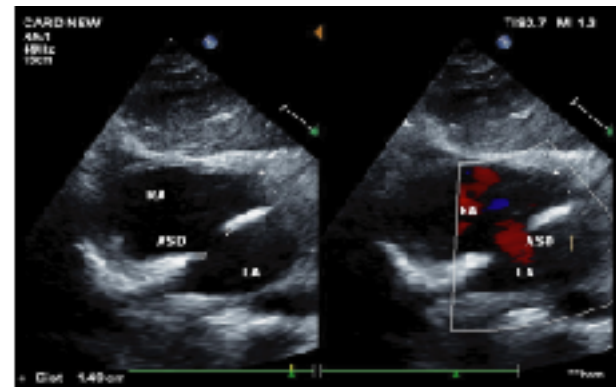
Doppler Echocardiography shows ASD (Secundum) flow.
